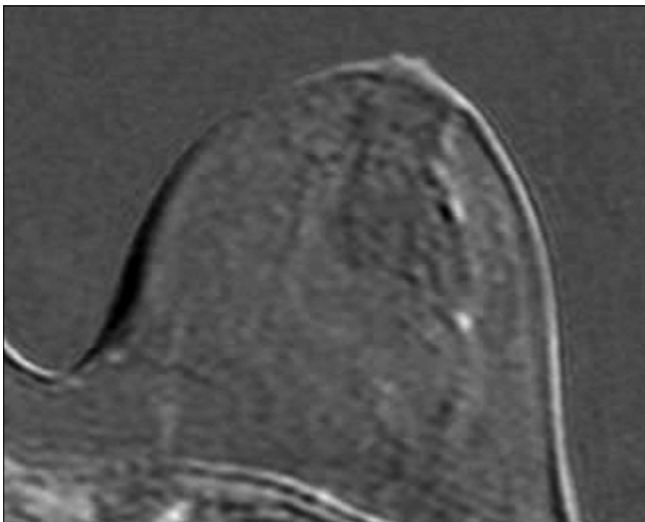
Post-treatment subtraction MRI images of Case 1 MRI not showing any pathological mass lesion or enhancement in the left breast. MRI response type was evaluated as "complete response"
